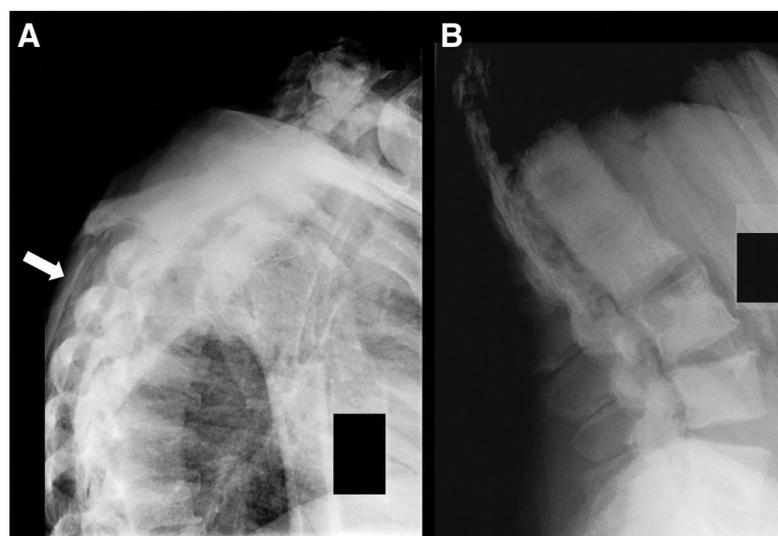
A, Lateral radiograph of the upper thoracic spine demonstrates diffuse osteosclerosis of the vertebral bodies that obscures the bony trabeculae. There is calcification of the supraspinal ligament (arrow) and exaggerated kyphosis. Endplate remodeling with intervertebral disc space narrowing is consistent with moderate degenerative disc disease. B, Lateral radiograph of the lumbar spine demonstrates markedly increased density of the vertebral bodies and posterior elements resulting in a dense, chalky appearance of the bone and loss of the normal trabecular pattern. Increased density of the ribs is also noted. No ligamentous calcification or ossification is identified. There is mild, multilevel, degenerative disc disease with endplate remodeling.
